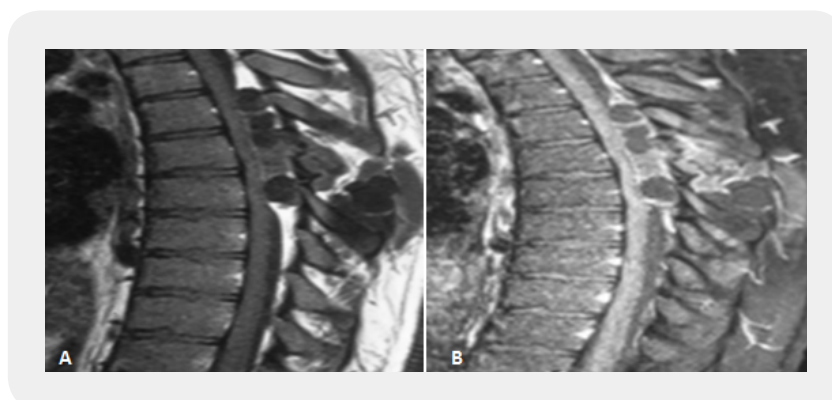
T1-weighted sagittal spine MRI without (a) and with (b) gadolinium injection: extradural, multi-vesicular mass, extending from T5 to T8, hypointense, and without secondary enhancement
